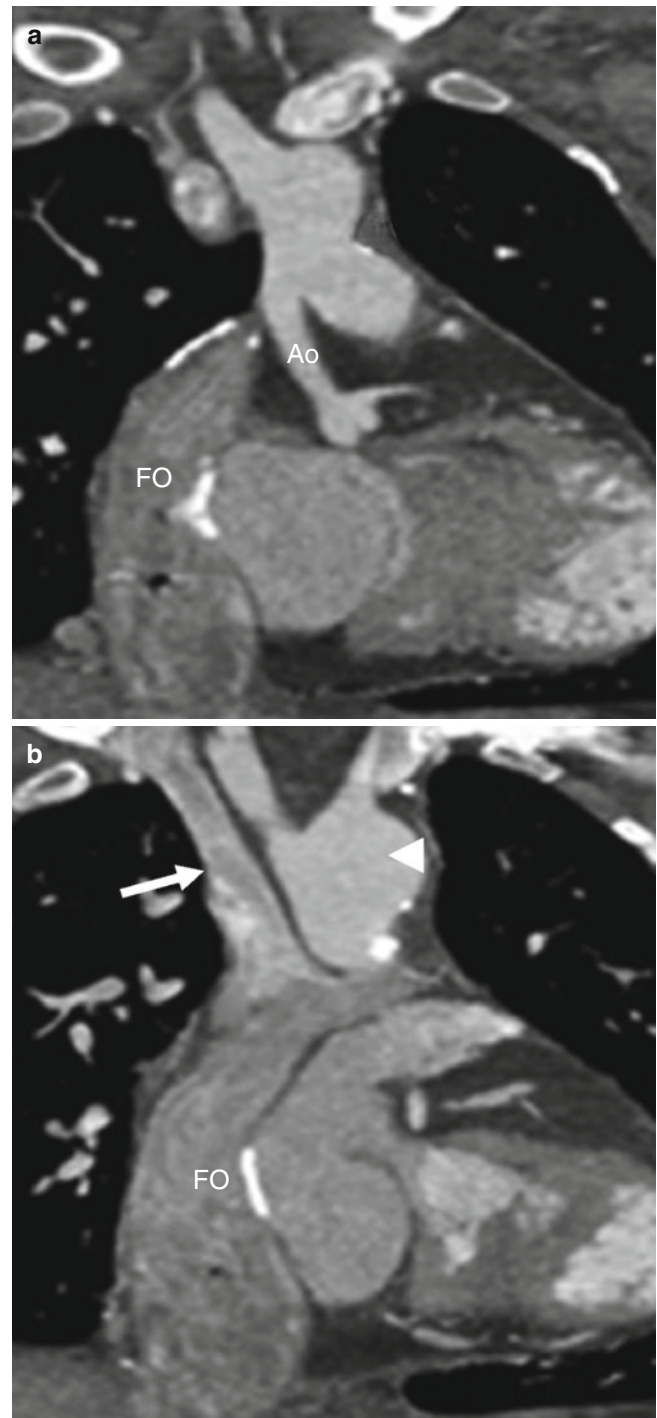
Stage III of the modified Norwood procedure. This example is from a 20-year-old man with mitral and aortic atresia who underwent a three-stage Norwood operation prior to age 3 years and was asymptomatic at the time. In stage III, a Fontan procedure is performed. This computed tomography (CT) was performed to evaluate right ventricular systolic function and to assess the Fontan pathway. Panels (a) and (b) are oblique coronal CT scans showing a severely hypoplastic ascending aorta (*Ao*), neoaorta (*arrowhead*), patent Glenn (superior vena cava to right pulmonary artery anastomosis, *arrow*), and inferior vena cava to right pulmonary artery Fontan (*Fo*) connection (Images courtesy of Kelly Han, M.D., Minneapolis Heart Institute, Minneapolis, MN)
